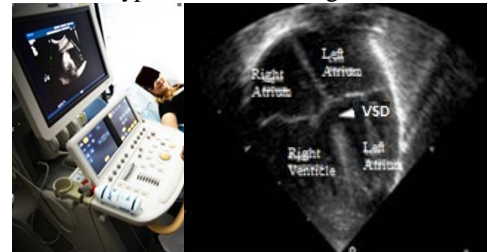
Fetal Echocardiography and typical image
